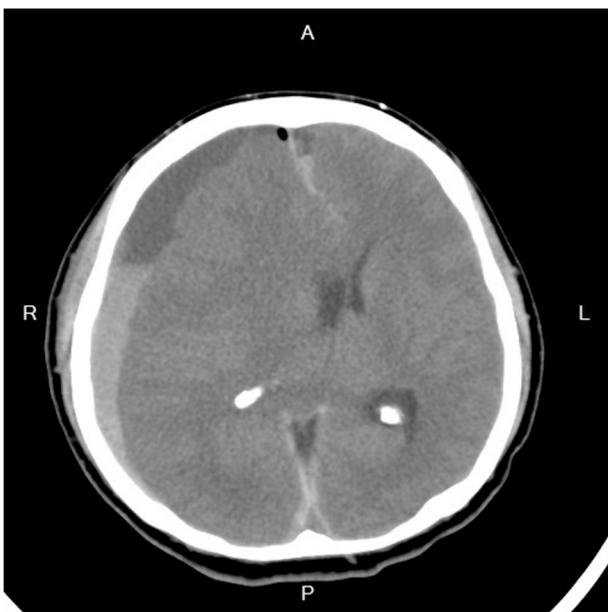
Brain CT showed reappearance of subdural hematoma two days after the subdural drain removal.
